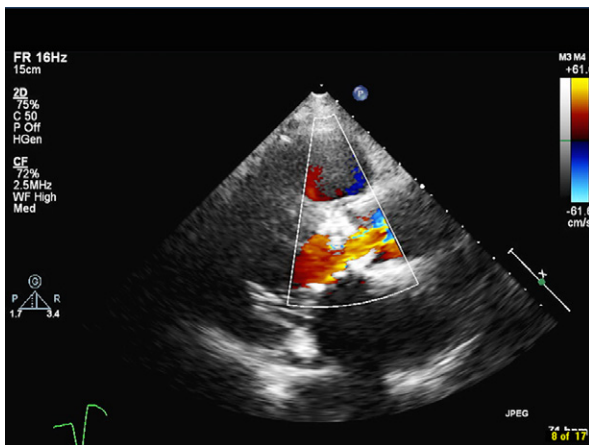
Transthoracic echocardiogram (parasternal long-axis view) shows a trace of intravalvular aortic insufficiency and no paravalvular leak.
